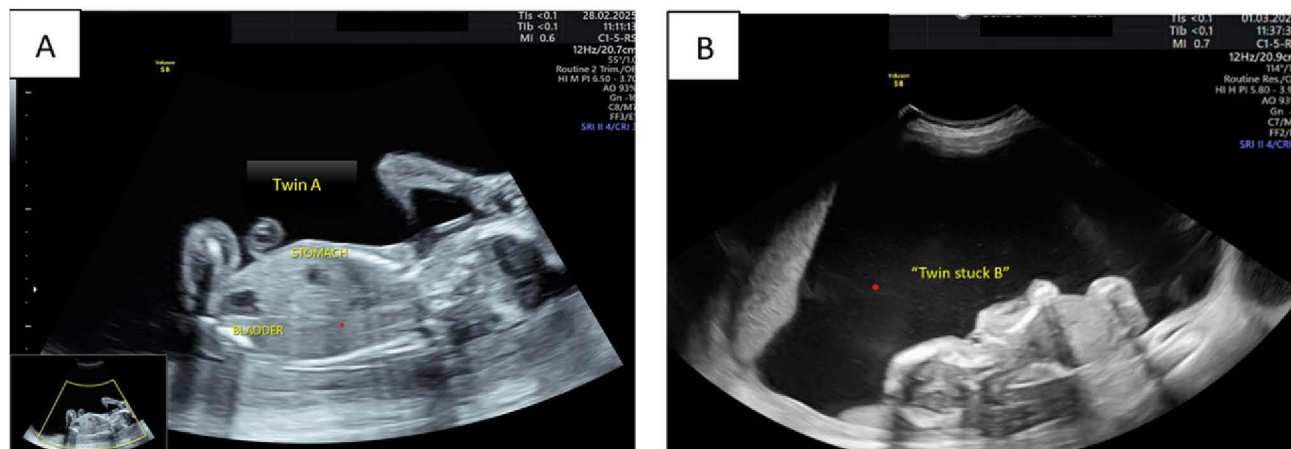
Ultrasound examination prior to intervention. (A) Twin A (recipient) shows polyhydramnios with a visible urinary bladder. (B) Twin B (donor) presents with severe oligohydramnios, positioned against the posterior uterine wall (“stuck twin”) with an unvisualized urinary bladder. These findings confirm the classic polyhydramnios-oligohydramnios sequence characteristic of Quintero Stage II TTTS.
